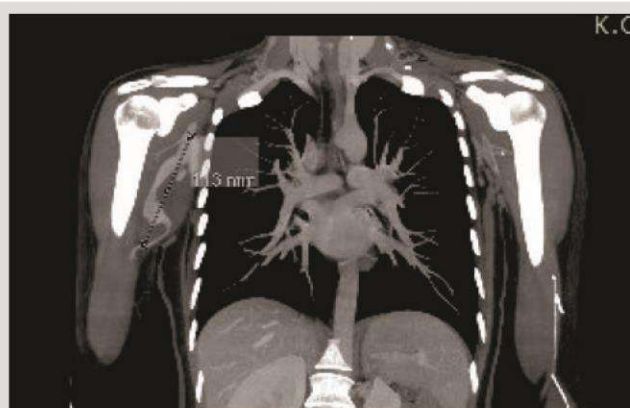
CTA finding (coronal view).
